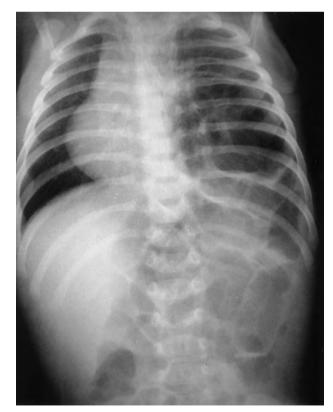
Diaphragmatic hernia. Chest radiograph of a newborn infant showing the characteristic picture seen with a posterolateral diaphragmatic hernia (Bochdalek hernia) with absence of the left diaphragmatic shadow, the left chest filled with gas-filled loops of bowel, and the heart and mediastinum shifted to the right.
